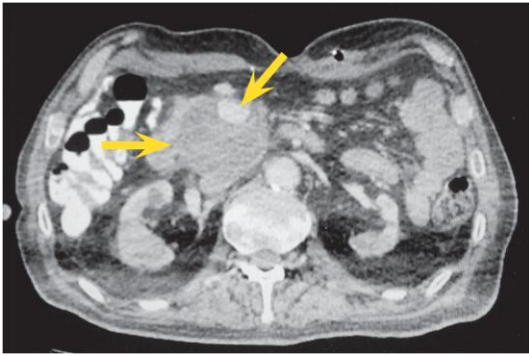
Computed tomography. Partially thrombosed false aneurysm of a small intestine artery
